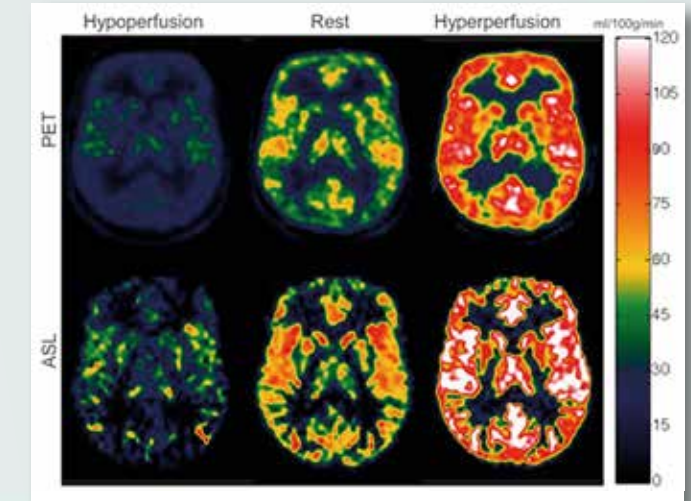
Examples of simultaneously obtained $^{15}\text{O}\text{-H}_2\text{O}$ PET (top row) and arterial spin labelling MRI (lower row) cerebral blood flow measurements from a healthy volunteer during hyperventilation (left), in rest (middle) and after acetazolamide (right). All measurements were obtained from the same volunteer on the same session. Data presented at Brain and Brain PET 2017 in Berlin, 2017 (courtesy of PhD student O. Puig).
